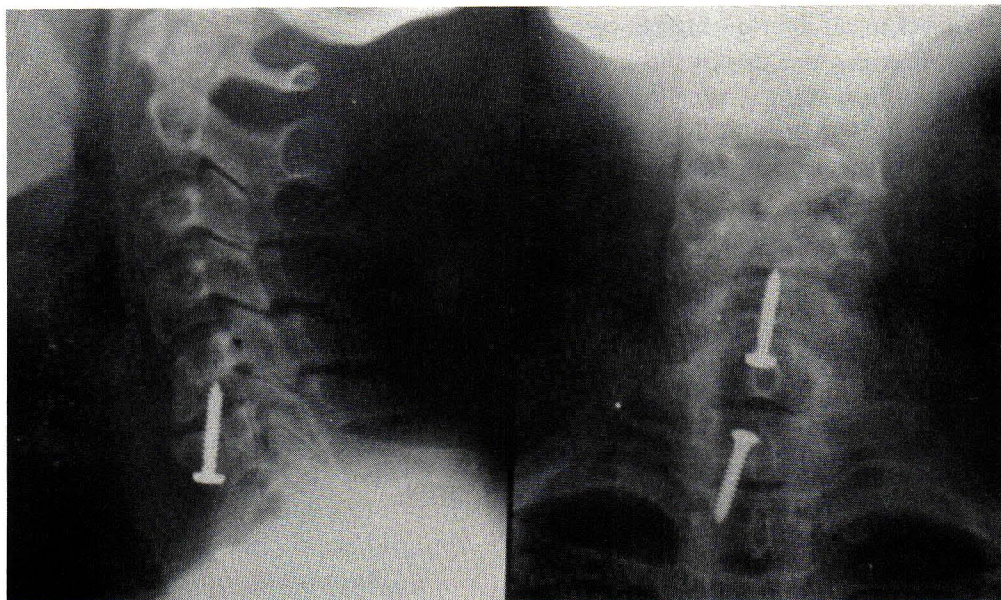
X-ray film of cervical spine showing interbody acrylic fusion between C₅ and C₇. Left : lateral view; Right : antero-posterior view.
